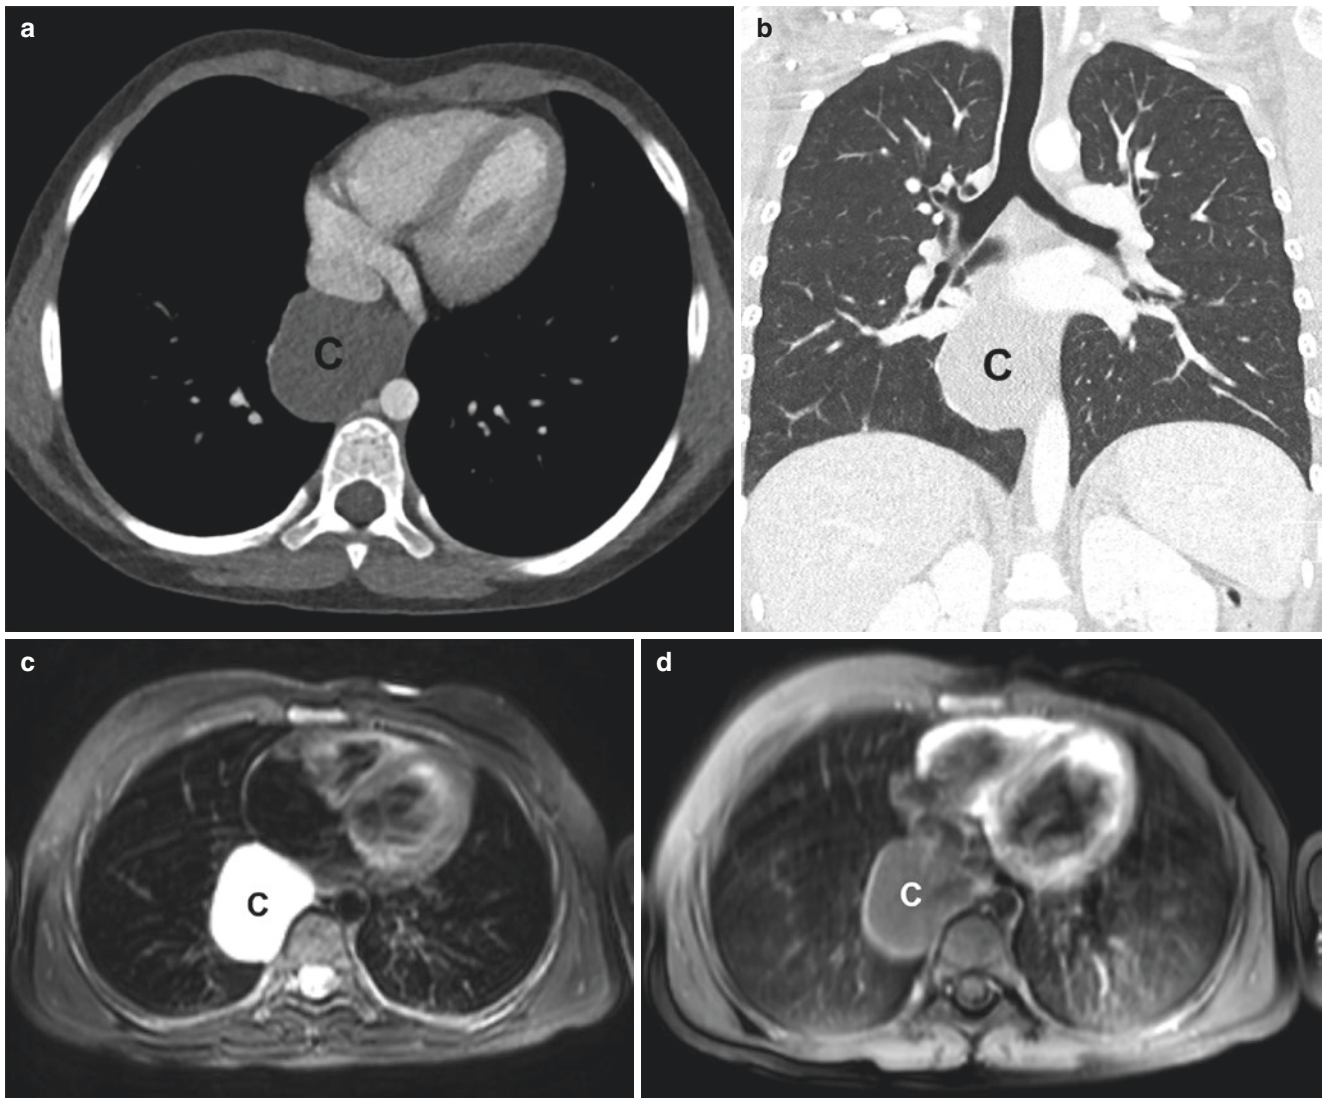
Bronchogenic cyst in a 7-year-old girl. (a) Axial enhanced soft tissue window setting CT image shows a thin-walled cyst (C) in the right posterior mediastinum containing simple fluid density. (b) Coronal enhanced lung window setting CT image shows the thin-walled cyst
